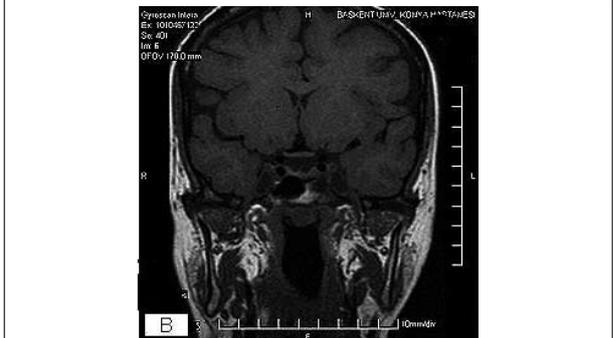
Coronal T1-weighted image showing the decrease in pituitary size due to regression of haematoma
